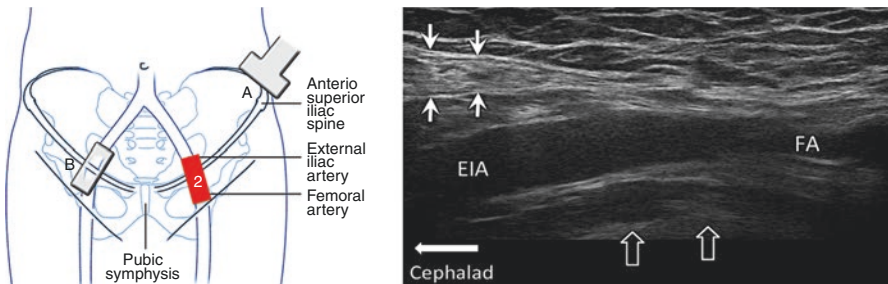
Figure showing the position of the ultrasound transducer (red square 2) and the corresponding sonography. Line bold arrow, pubic ramus; arrows, inguinal canal, FA femoral artery, EIA external iliac artery. (Reprinted with permission from Philip Peng Educational Series)
